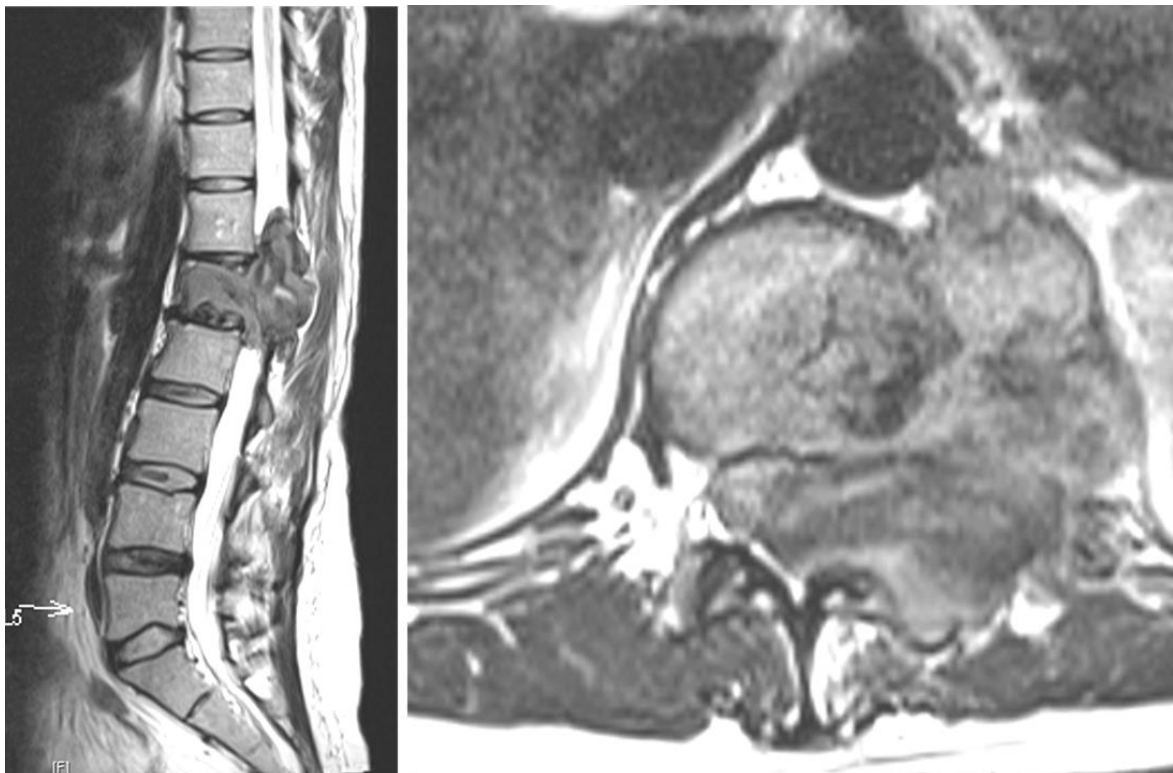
Pre-operative MRI demonstrating extra-osseous tumour extension, and extension into the epidural space
